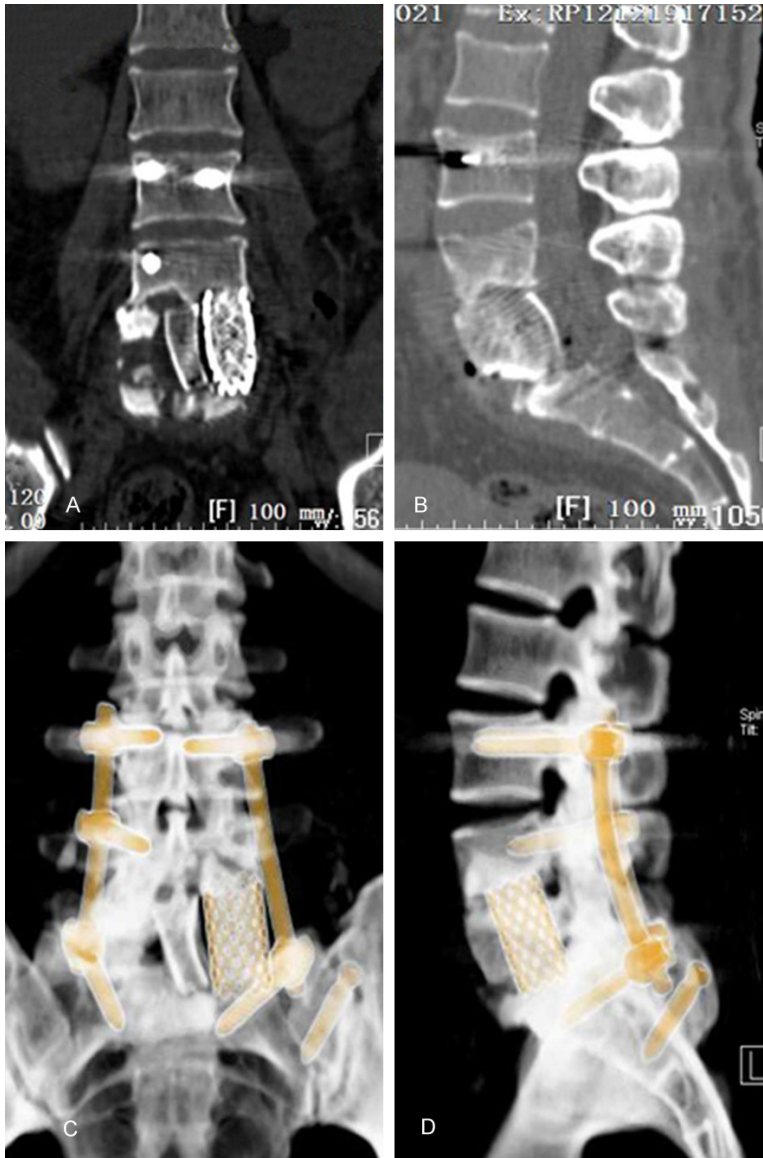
Internal fixation after surgery detected by CT. A, B: Short-term examination. C, D: 12-month follow-up examination.
